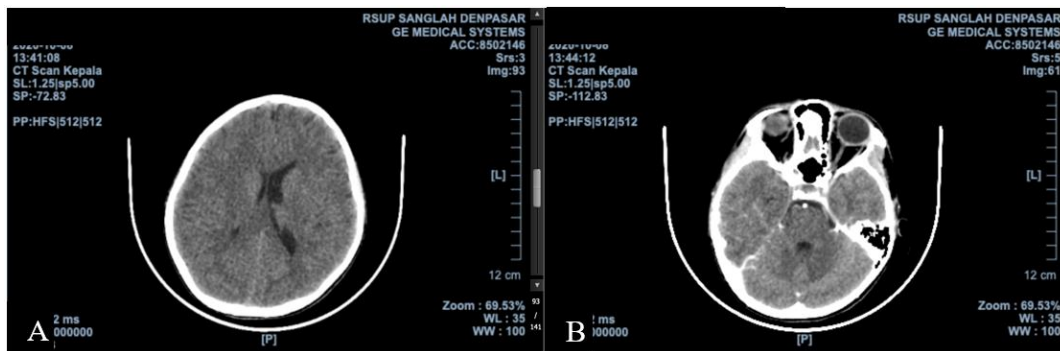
Head CT Scan showed no signs of hemorrhage, intracerebral or intracerebellar space-occupying lesion, hypertrophy *chonca* nasal inferior bilateral, blurring in grey-white matter junction regio right parietal *lobus* with narrowing of right lateral ventricle, suspected right hemisphere edema.
